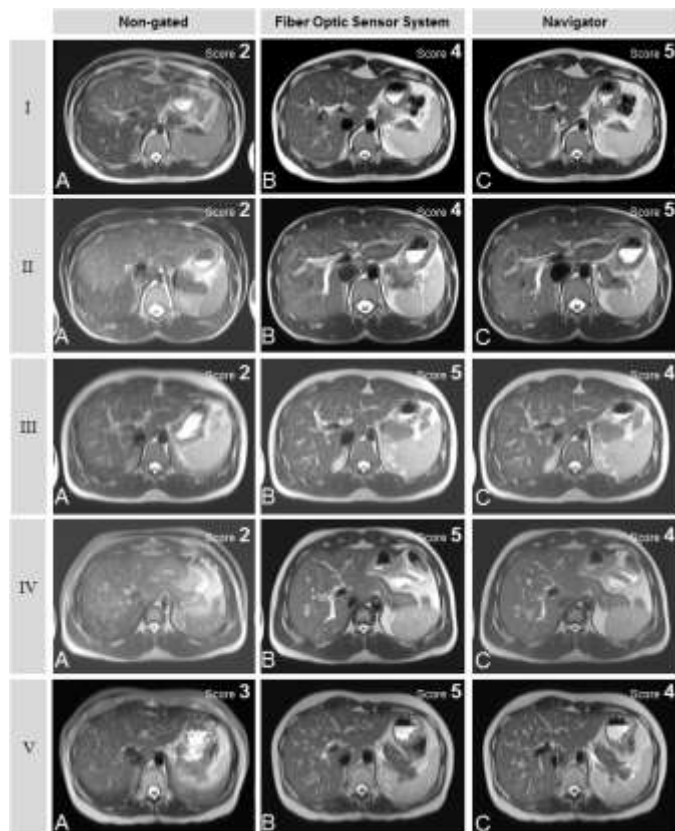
A comparison of liver MRI images obtained at 1.5T from 5 healthy subjects (Subject *I-V*) using FOS for respiratory-gated image acquisition (*B*) with Navigator echoes based respiratory-gated images (*C*) and images obtained without any respiratory-gating (i.e. without motion compensation / non-gated) (*A*). Motion artifacts were mild or absent and anatomic structures such as the portal veins can clearly be seen in the FOS-gated images. FOS-gated images were generally graded score 4 and above for good to excellent overall image quality. In some instances, FOS-gated images even scored the highest for overall image quality among all three imaging techniques (see subjects *III-V*). The presence of the fiber optic sensor mat inside the MRI gantry during imaging did not lead to any obvious image distortions in all images.
